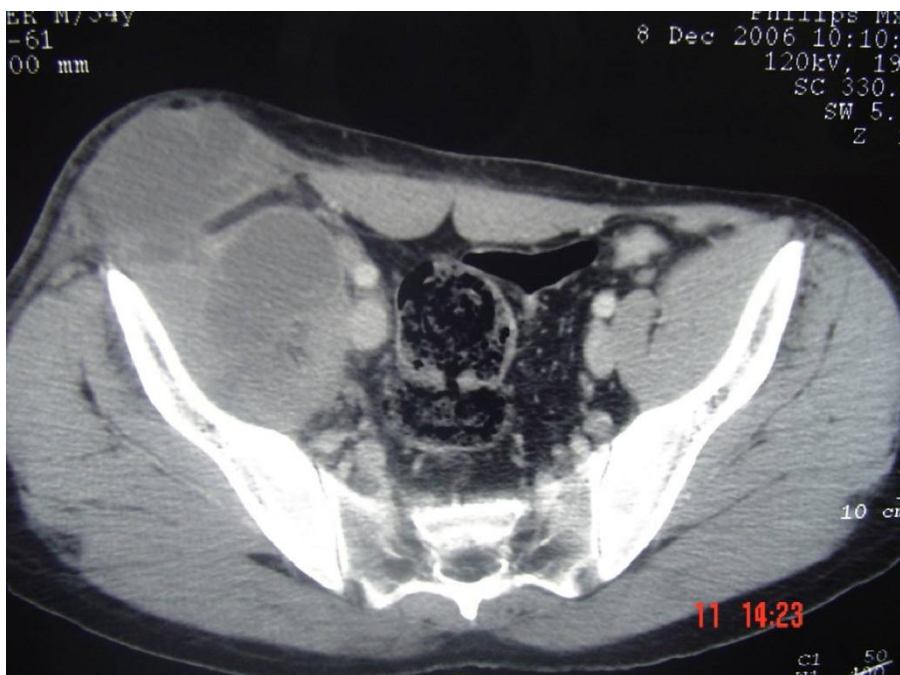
The abdominopelvic CT scan image shows a collection of the right iliopsoas muscle.
